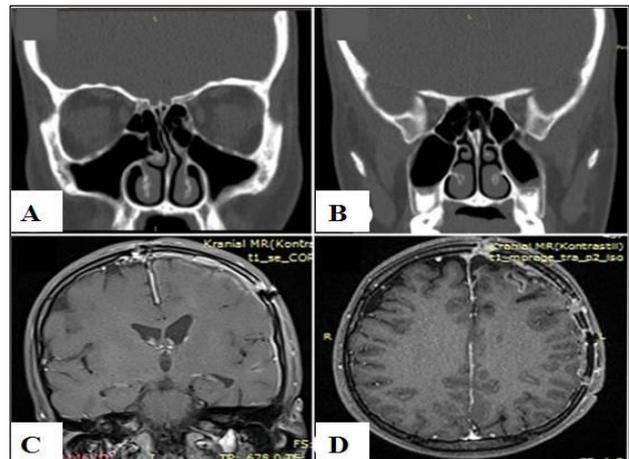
Postoperative coronal sections of paranasal CT images showing no opacity in paranasal sinuses suspecting sinusitis (a, b). No abscess formation in the first year follow up cranial MRI (c, d).
